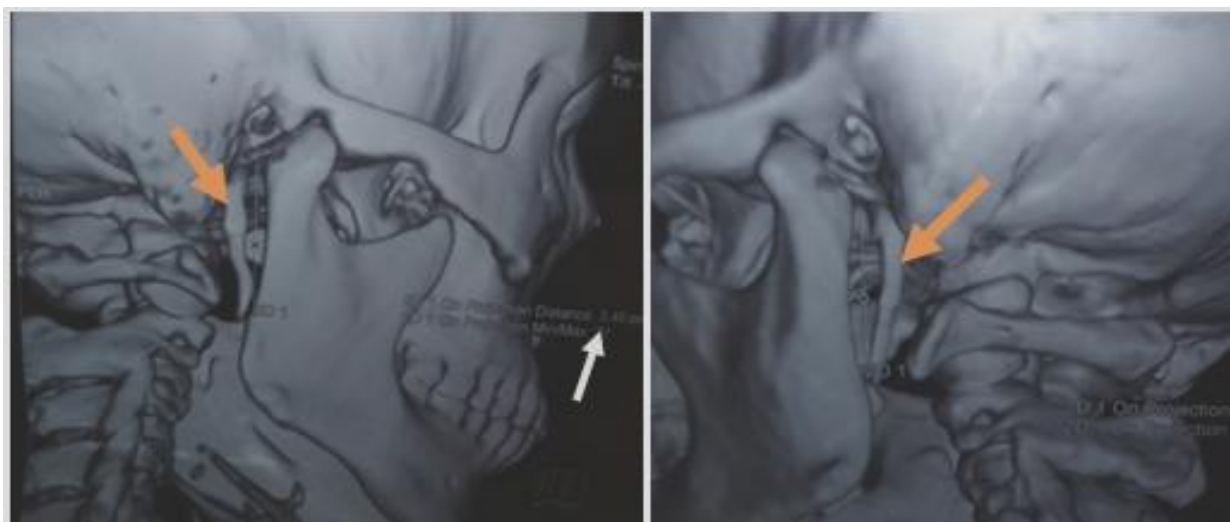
Brownish arrow pointing at elongated styloid process whereas white arrow points towards the length of the styloid process(3.45cm) as printed on the CT scan film.
